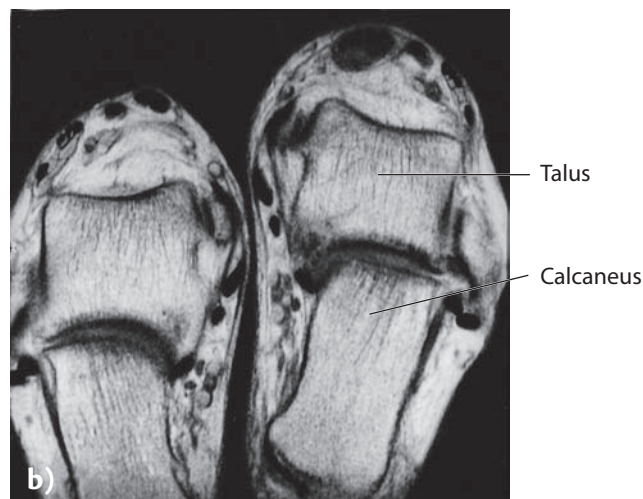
The tendon to the tibial anterior muscle can be overloaded and painful. a) Localization for potential tenderness over the tendon; b) magnetic resonance imaging will verify the diagnosis; c) during ice skating and figure skating tight lacing can increase the friction against the tendon and the tendon sheath and cause inflammation.
